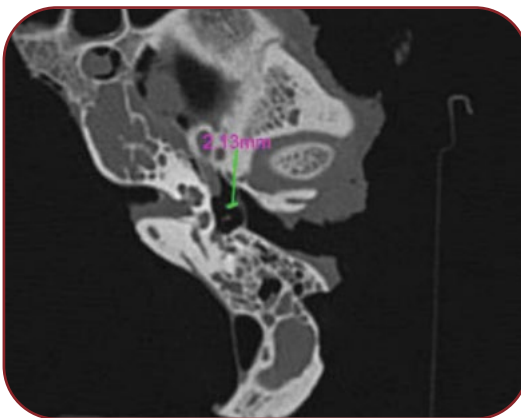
Thickness of incudostapedial joint on a multi-detector computed tomography (MDCT) image
